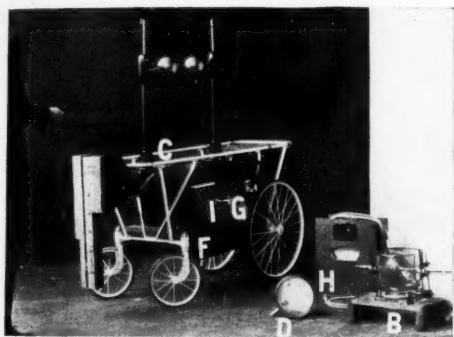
Semi-portable apparatus for testing X-ray machines.
